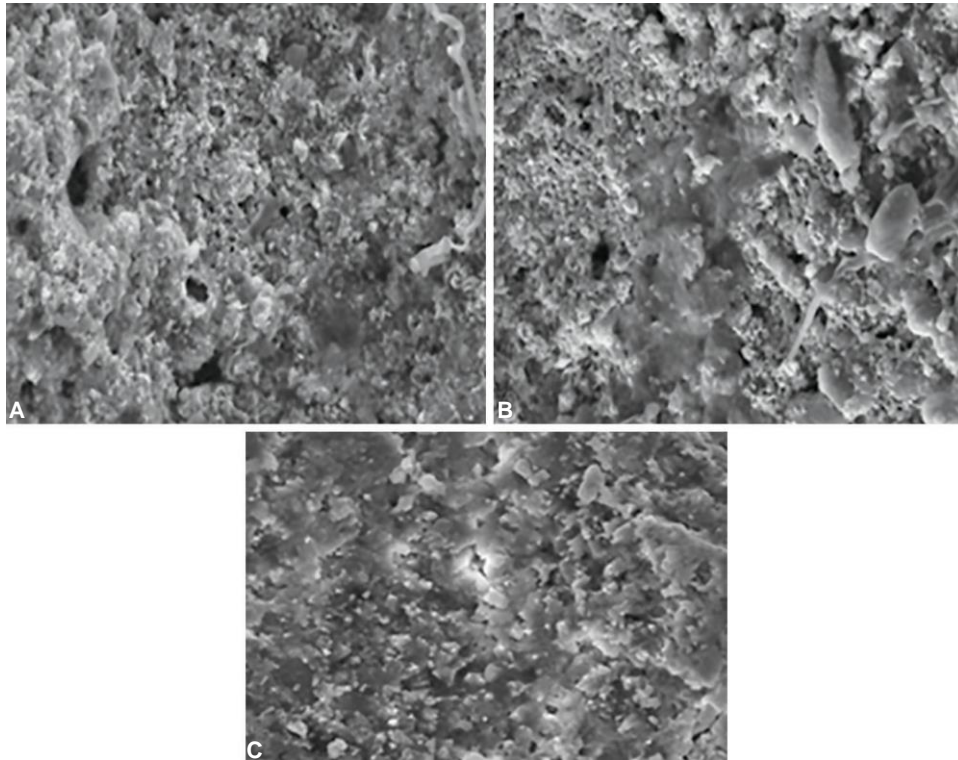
SEM evaluation of (A) rotary Files; (B) endoVac system; (C) ultrasonic Activation at coronal third
